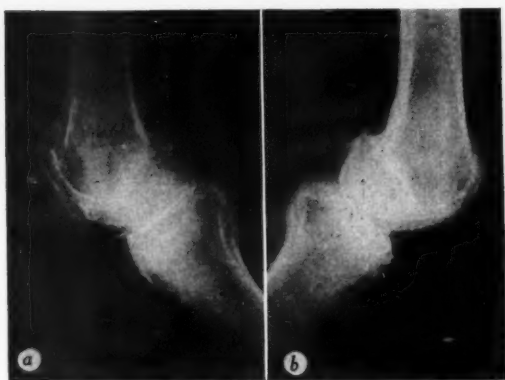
a*, Right and, *b*, left knees of patient represented in Figures 4 and 5. Roentgenograms taken two and a half years after operation, showing regeneration of right patella. Excellent clinical result. Range of motion 170 degrees to 60 degrees. "Was a complete cripple and now almost 100 per cent normal."
